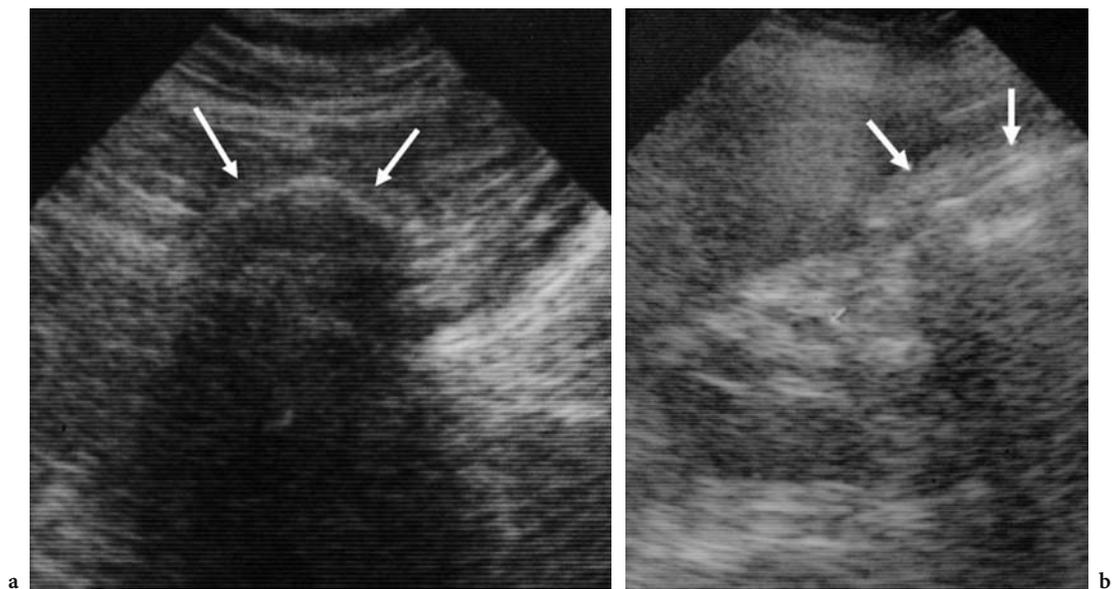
Gallstone ileus. a Sonogram shows hyperechoic arc-like echo with posterior acoustic shadow within a dilated loop of ileum, representing a large gallstone (*arrows*). b Sonogram of the right upper abdomen discloses the gallbladder, which is empty (*arrows*)
